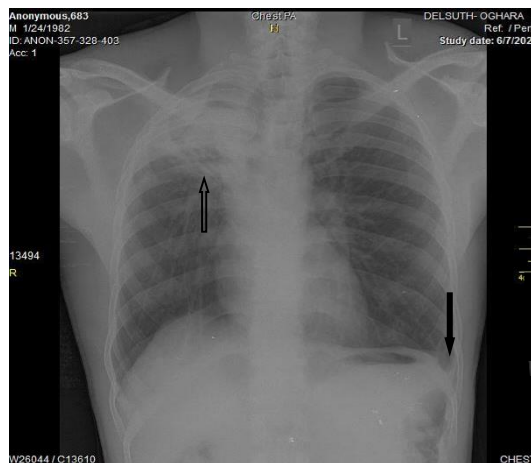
Posteroanterior chest radiograph of a 38-year old male HIV sero-negative PTB patient showing right upper lung zone consolidation with fibrocystic changes (white arrow) and loss of lung volume as evidenced by ipsilateral tracheal shift. There is also blunting of the left costophrenic angle possibly due to minimal pleural effusion. (black arrow).
